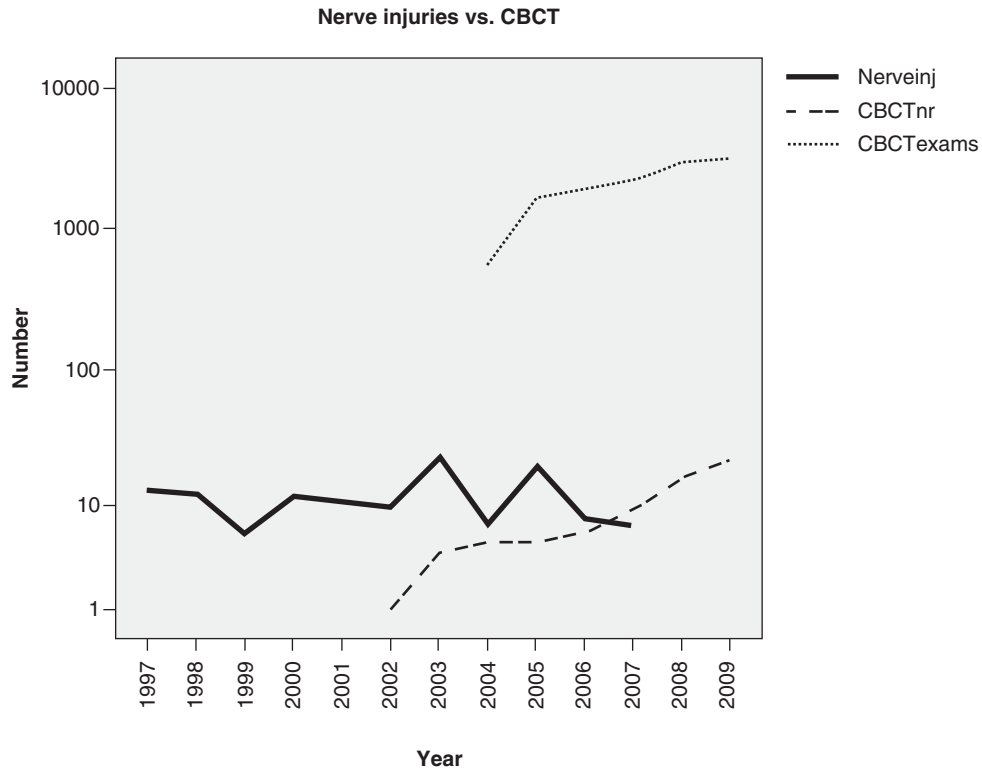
The number of new CBCT devices in Finland during the years 2002–2009, the number of reimbursed CBCT examinations in Finland during the years 2004–2009 and the number of reported permanent IAN injuries related to the removal of mandibular third molars during the years 1997–2007.
